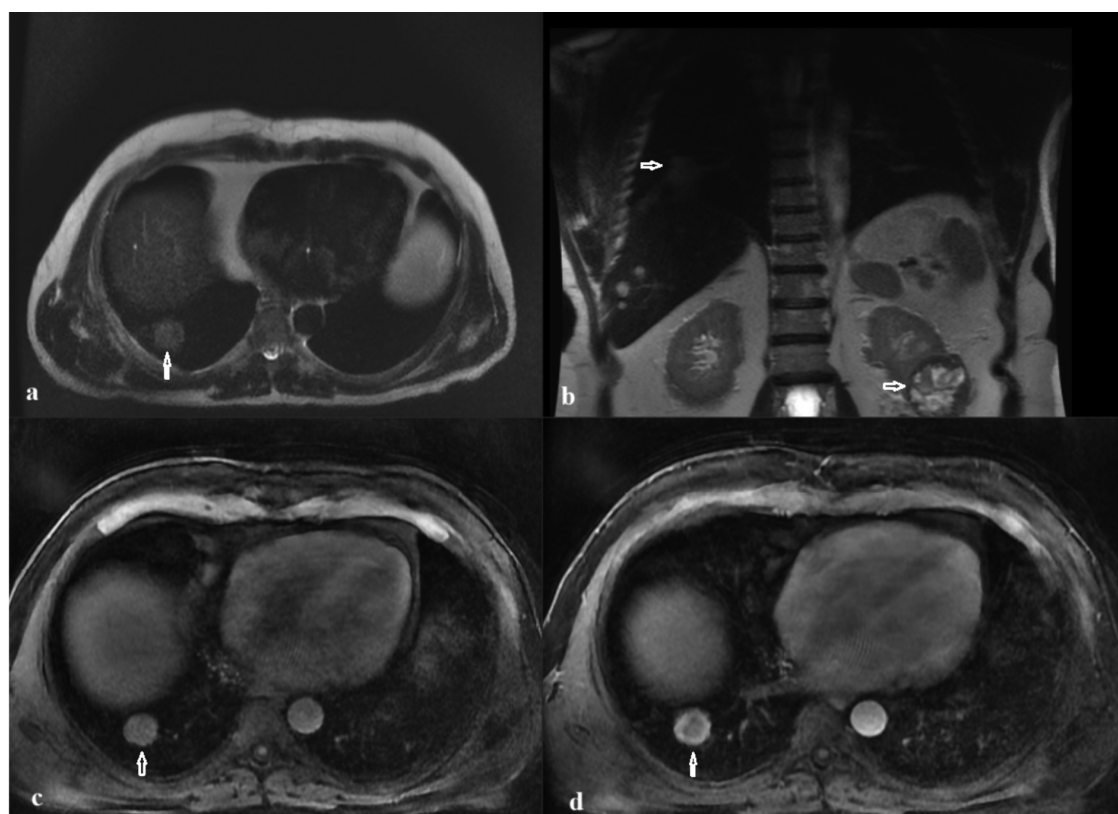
a) In the thorax sections included in the abdominal MRI examination, a lesion with heterogeneous signal intensity on T2WI in the lower lobe of the right lung is noted, b) Coronal image showing the lesion in the right lung and left kidney, c,d) When non-contrast fat-suppressed T1 and contrast-enhanced examination is evaluated, it is seen that the lesion in the lung is peripherally enhanced.
